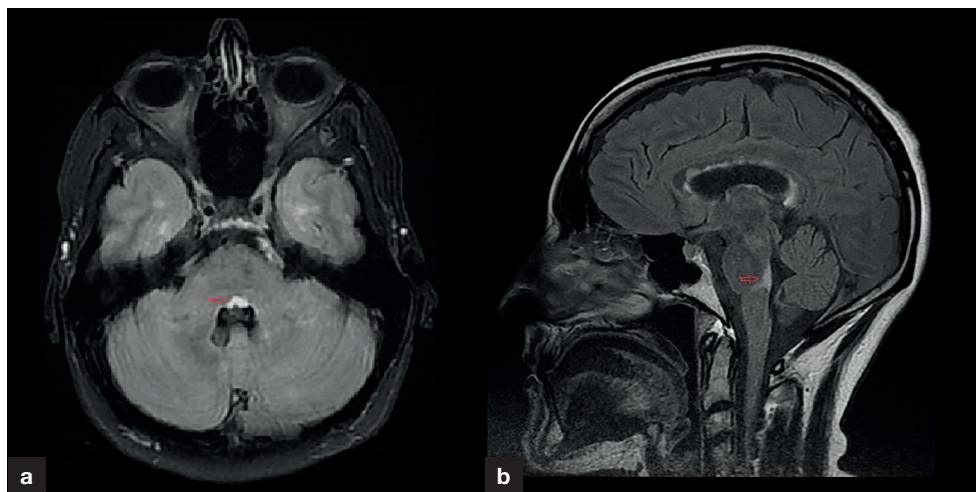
a. Axial FLAIR image shows a midline T2 hyperintense lesion (arrow) in the ventral pons abutting the floor of the 4th ventricle. Anatomically, this region corresponds to the site of the medial longitudinal fasciculus which is involved bilaterally in this case. b. Midline sagittal FLAIR sequence confirms the location of a triangular T2 hyperintensity (arrow) in the lower dorsal pons.
